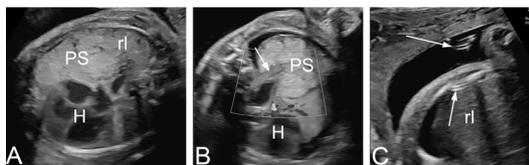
The same fetus as in Figure 1 with pulmonary sequestration complicated by severe hydrothorax treated with thoraco-amniotic shunt. A: pleural effusion is completely drained into the amniotic fluid. The right lung (rl), the heart (H), and pulmonary sequestration (PS) are visible; B: Color Doppler imaging shows the vascular pedicle with the afferent artery originating from the thoracic aorta (arrow); C: correct position of the thoraco-amniotic shunt with one end visible in the pleural space and the other within amniotic cavity (arrows).
